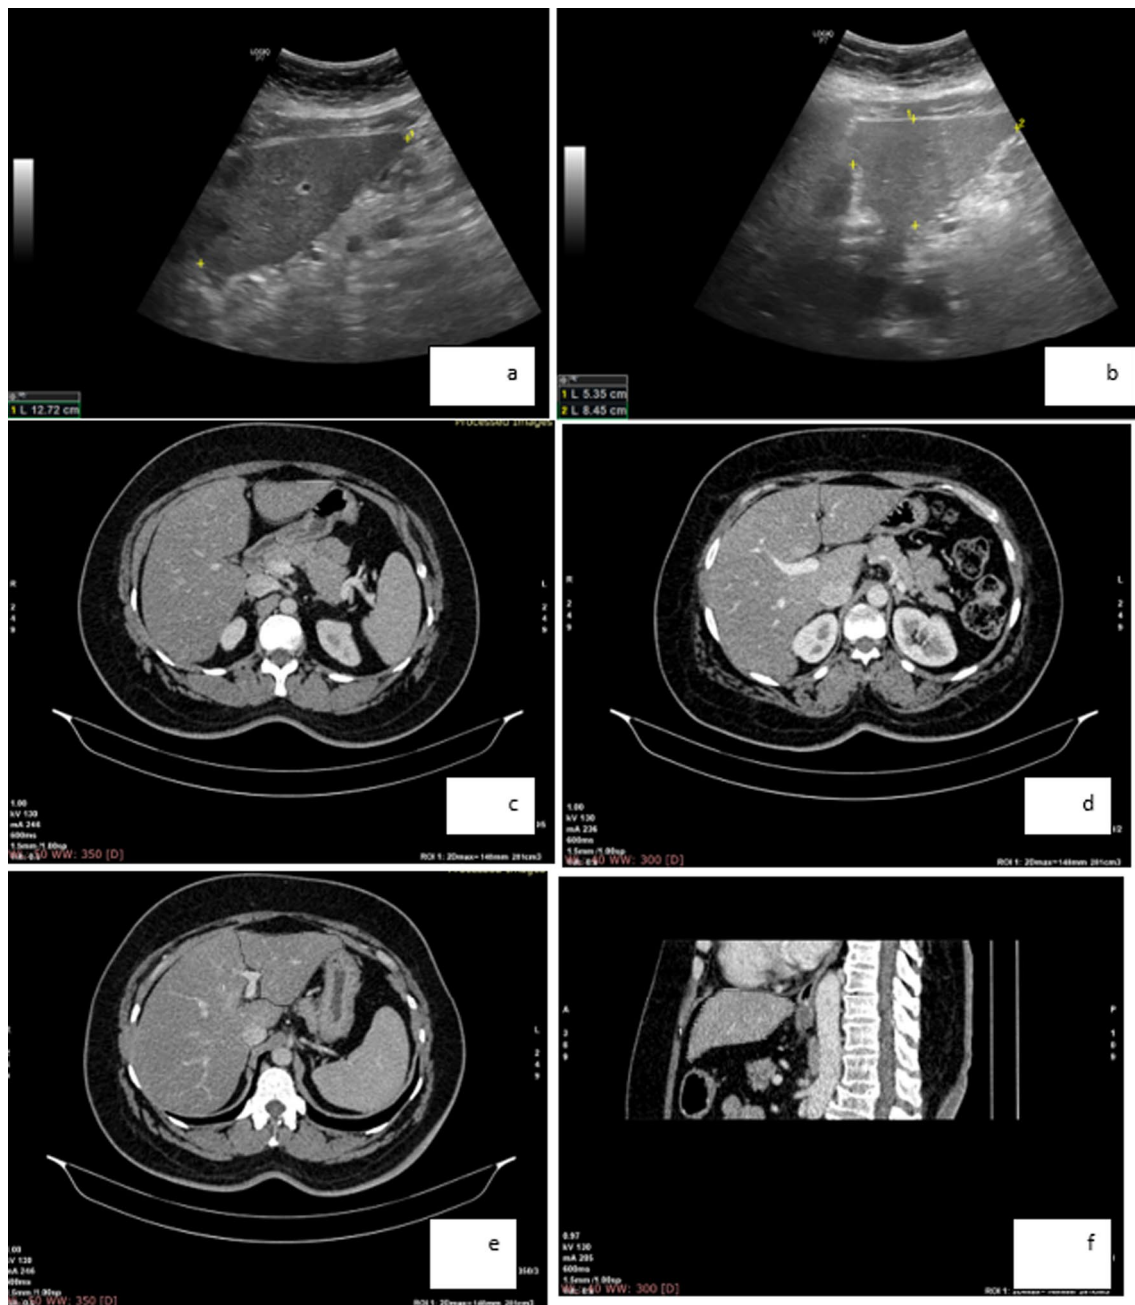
a–f US and CT images for a 45 years old female with a history of diabetes and hypertension, his BMI=39. a and b US images measuring the height, length, and width with the estimated LHL volume by ultrasound = 303.1 cm³. c–e axial CECT images and f sagittal CECT image estimating the LHL volume = 280 cm³
